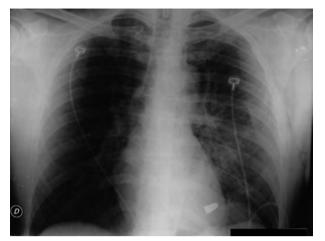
Radiography showing bullet lodged in chest cavity.
